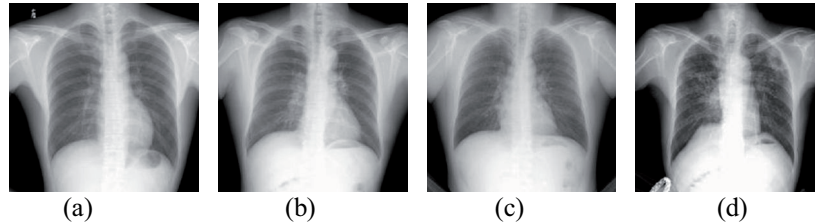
Normal and pneumoconiosis chest X-ray images. (a) normal, (b) stage I, (c) stage II, (d) stage III.
